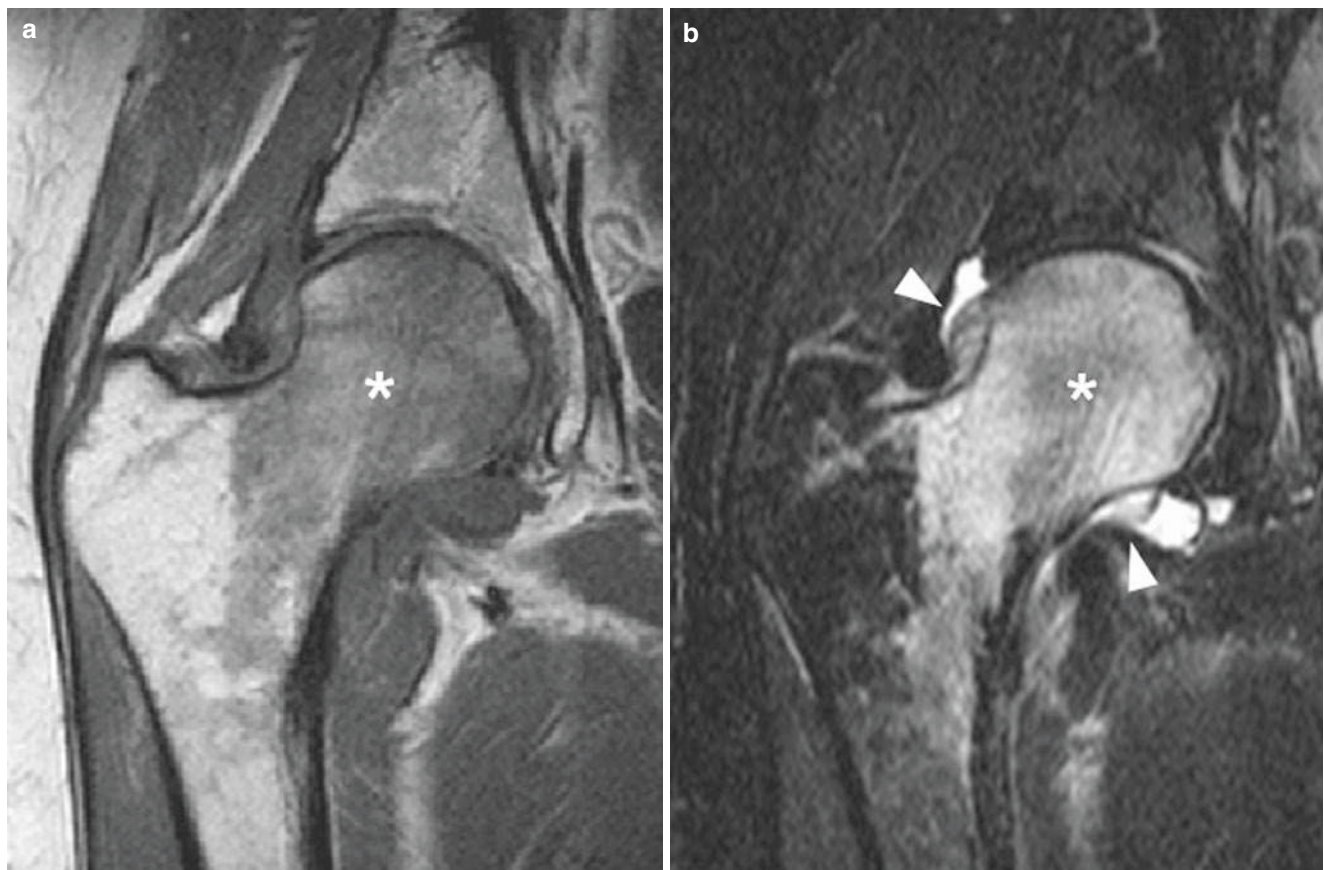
(a, b) Transient bone marrow edema syndrome of the hip. (a) Coronal T1-weighted TSE image and (b) corresponding STIR TSE image show extensive bone marrow edema (asterisk) of the proximal
